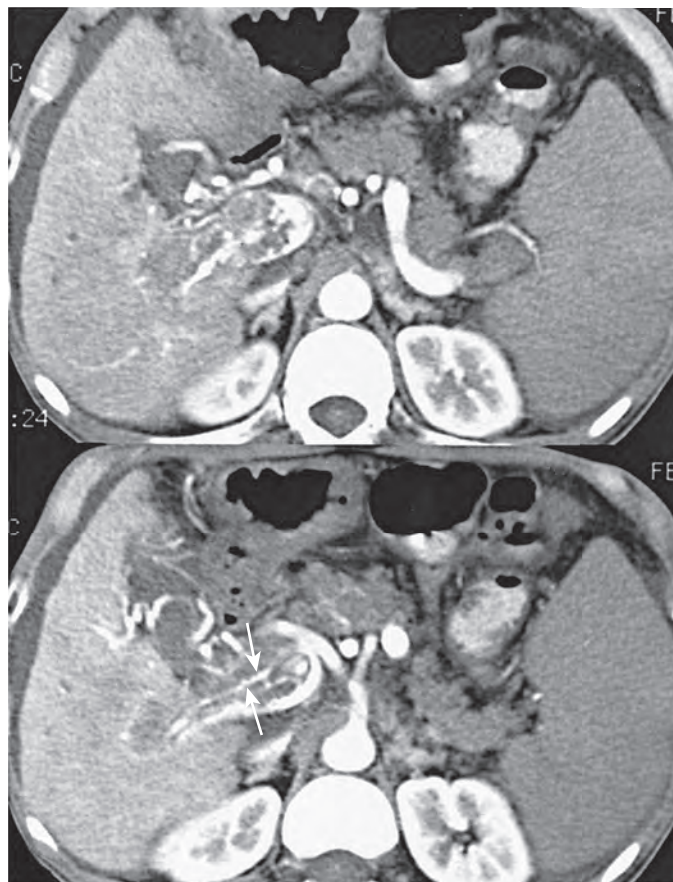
Portal vein tumor thrombus: CT features. There is direct visualization of arterial neovascularity in tumor thrombus, producing a "streaks and threads" (arrows) appearance. (Case courtesy Richard L. Baron, MD, Chicago, Ill.)
